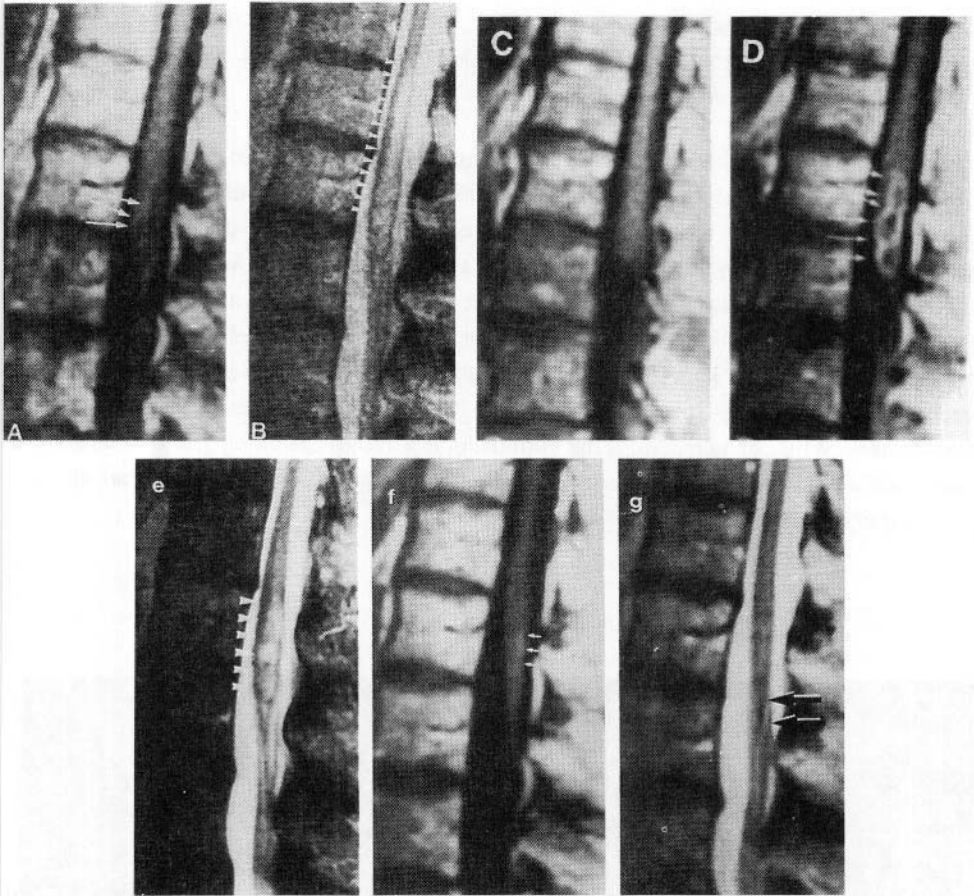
Intramedullary abscess. Sagittal contrast enhanced T1-weighted image (a) shows evidence of cord widening and low signal intensity in the conus. There is minimal enhancement (arrows) around the region of low signal intensity. T2-weighted image (b) shows high signal intensity in the central portion of the spinal cord (arrowheads). Follow-up MR study after 1 week, T1-weighted sagittal (c) image shows swollen cord. Postcontrast T1-weighted sagittal (d) image shows ring enhancement extending to the surface of the cord (arrows). T2-weighted image (e) shows intramedullary high signal at and above the conus (arrowheads). Follow-up after 3 months with sagittal contrast-enhanced T1-weighted image (f) shows subtle abnormal intramedullary enhancement (arrows) in the conus. The T2-weighted image (g) shows resolution of edema with a central region of low signal intensity, possibly representing hemosiderin deposition (arrows). (Reprinted with permission from Murphy KJ, Brunberg JA, Quint DJ, Kazanjian PH. Spinal cord infection: Myelitis and abscess formation. *Am J Neuroradiol* 1998; 19: 341-348.)
